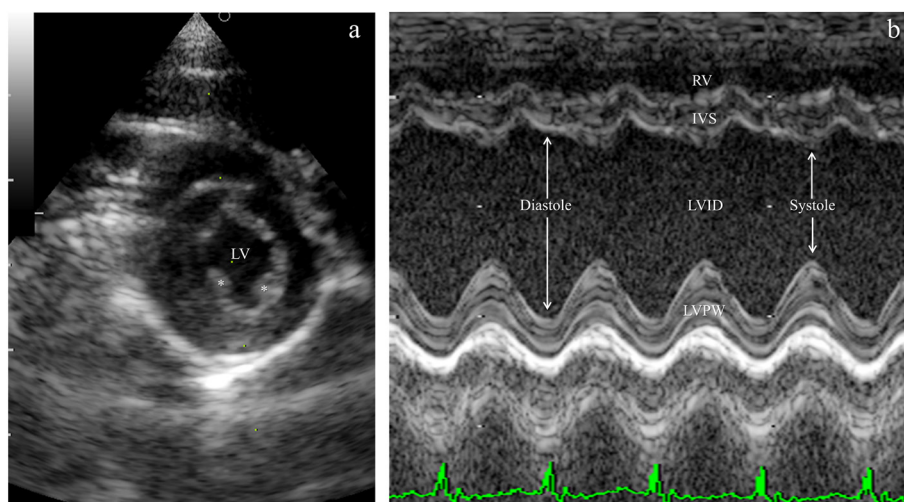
(a) Parasternal short-axis view at papillary muscle level; (b) Time-motion TM mode (or M-mode) of LV; RV = right ventricle; LV = left ventricle; * (asterisk) = papillary muscles. In this view, ventricular geometry was measured with interventricular septum (IVS), left ventricular internal diameter (LVID), and left ventricular posterior wall (LVPW) during systole and diastole. The measured line must be placed between papillary muscles for better view and accurate results.
